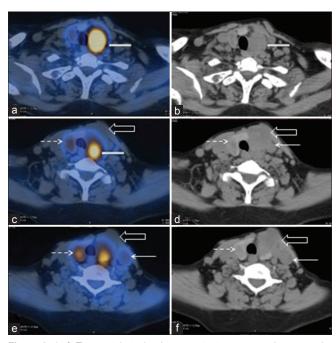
(a-f) Transaxial single-photon emission computed tomography Tc-99m-sestamibi images showed soft tissue density lesion just below the left lobe of thyroid with intense radiotracer uptake (thick arrow), irregular mass in the left lobe of thyroid (outlined arrow) with no tracer radiotracer uptake, hypodense lesion with mild uptake in the right lobe of thyroid (dotted arrow) and rounded left level IV cervical lymph nodes with mild tracer uptake (thin arrow)
